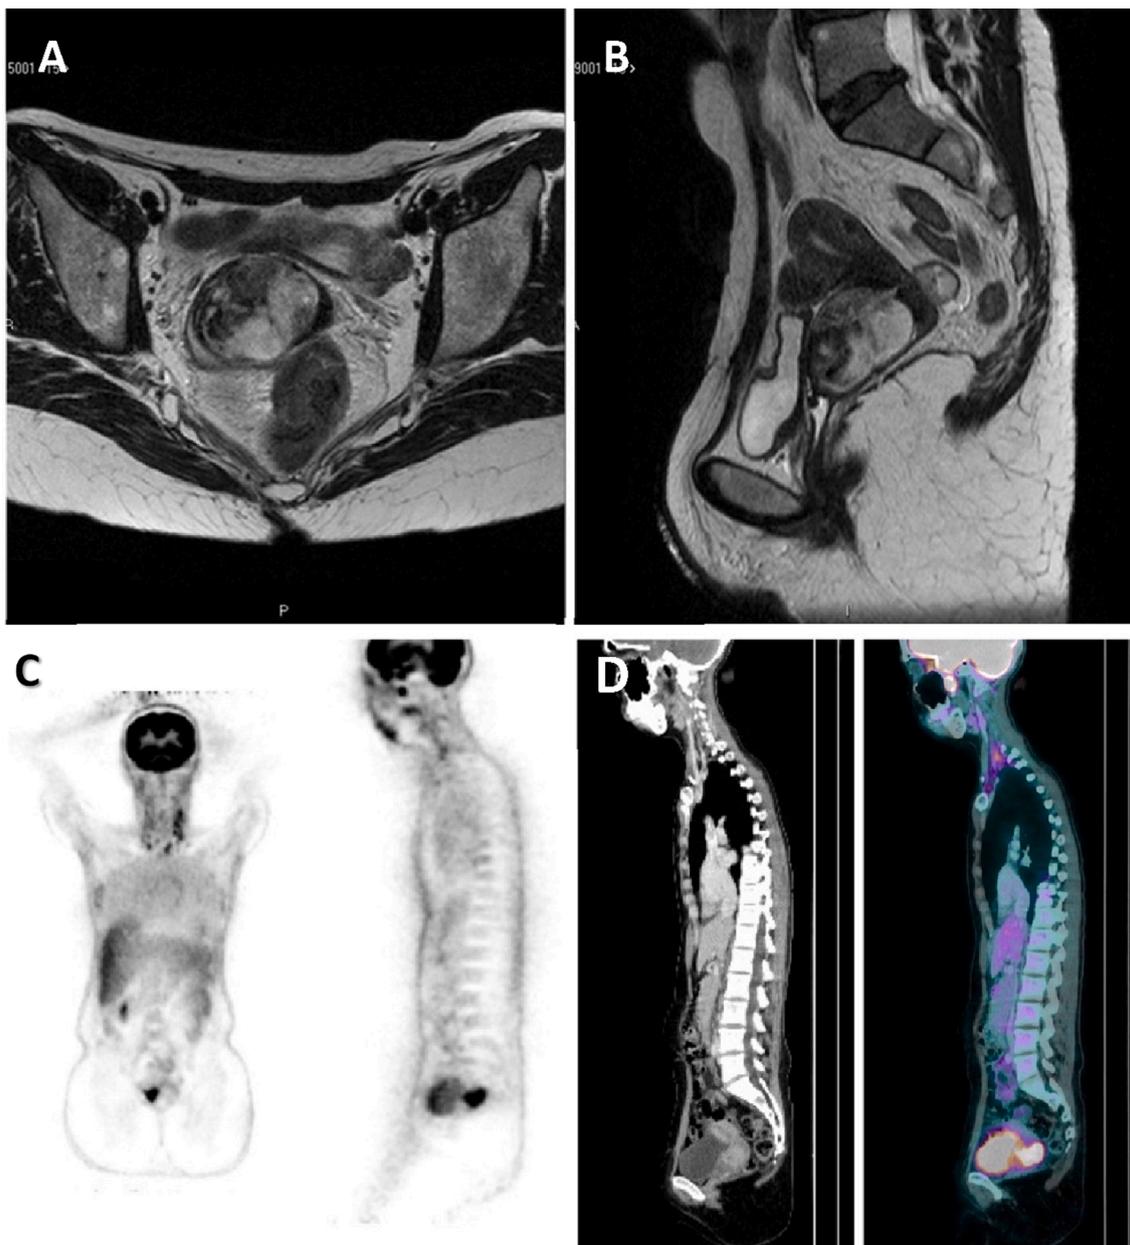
(A and B) Representative images of abnormal findings on the baseline MRI of the pelvis. (C and D) PET/CT scan images showing a hypermetabolic cervical lesion upon initial diagnosis.
